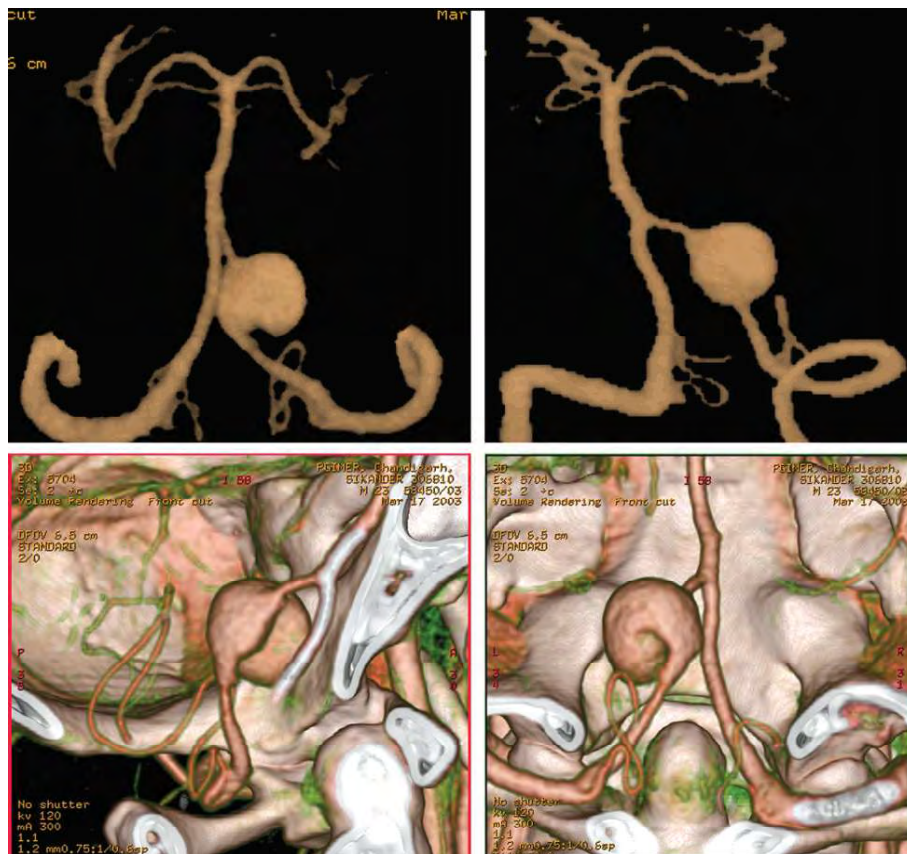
Computed tomography angiography—large posterior inferior cerebellar artery aneurysm (left)
